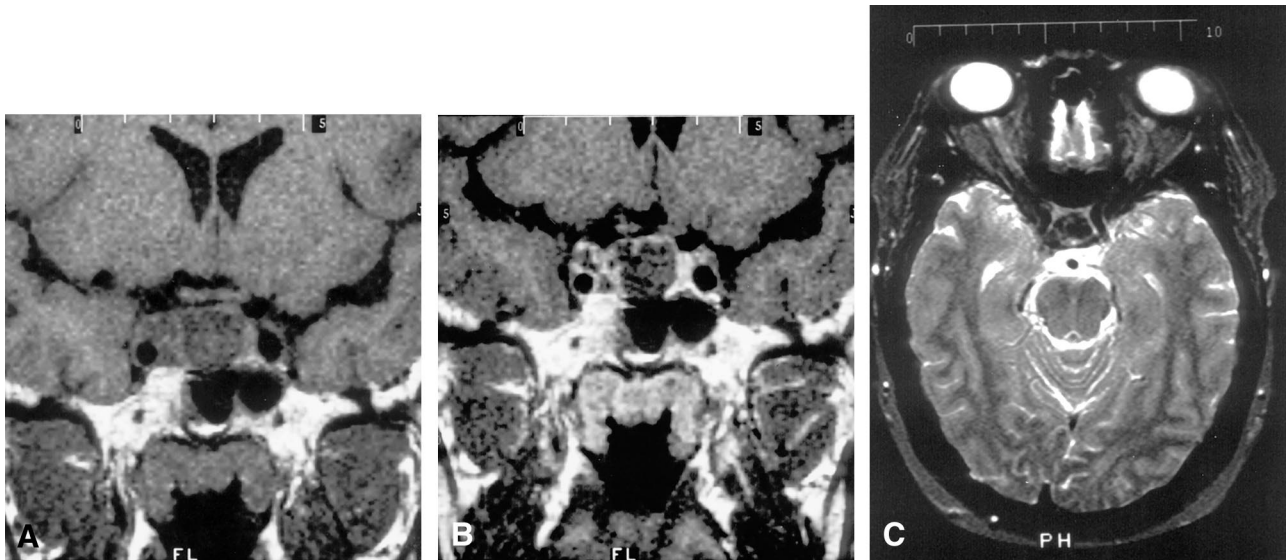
MR imaging of a mass arising from the pituitary gland.
